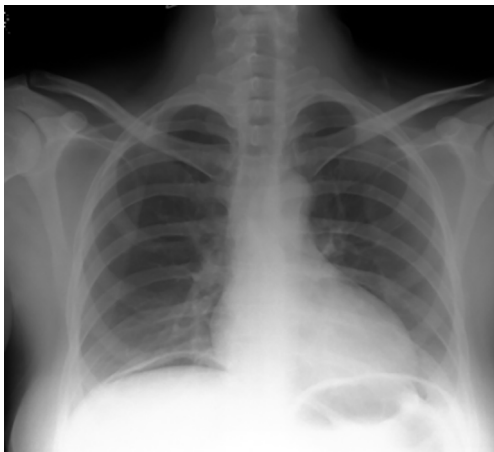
An erect chest X-ray showing free gas under the diaphragm.
